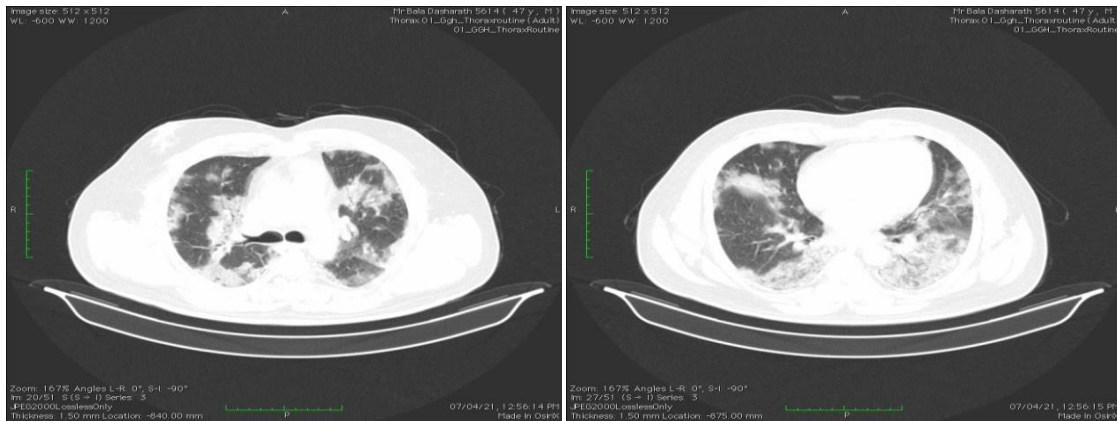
CT chest: shows patchy areas of GGO and consolidation in periphery in upper lobes
